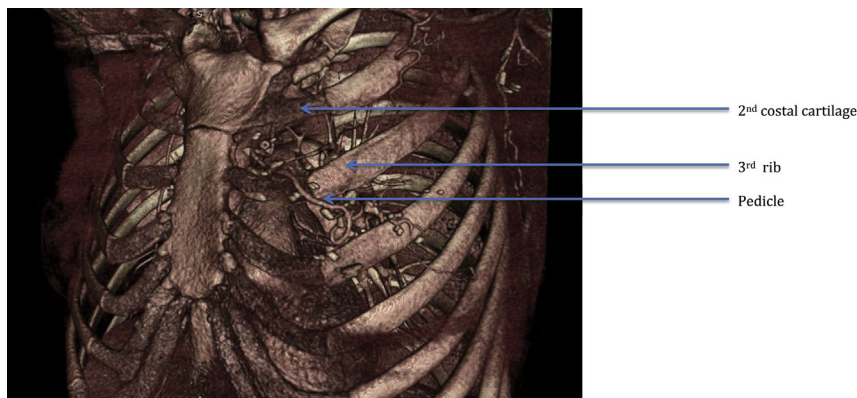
Three dimensional CT scan showing the microvascular anastomoses and free flap pedicle at the 2nd intercostal space, between the 2nd and 3rd costal cartilages.
